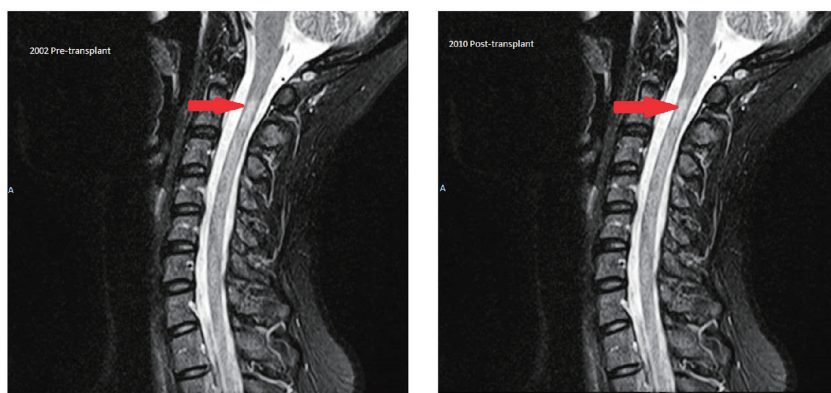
MRI cervical in 2002 (pre-transplant) showed area of high T2 signal intensity seen in C2 to C4. Surveillance MRI cervical spine done in 2010 (post-transplant) showed smaller C2 to C4 T2 cord signal (arrow).
